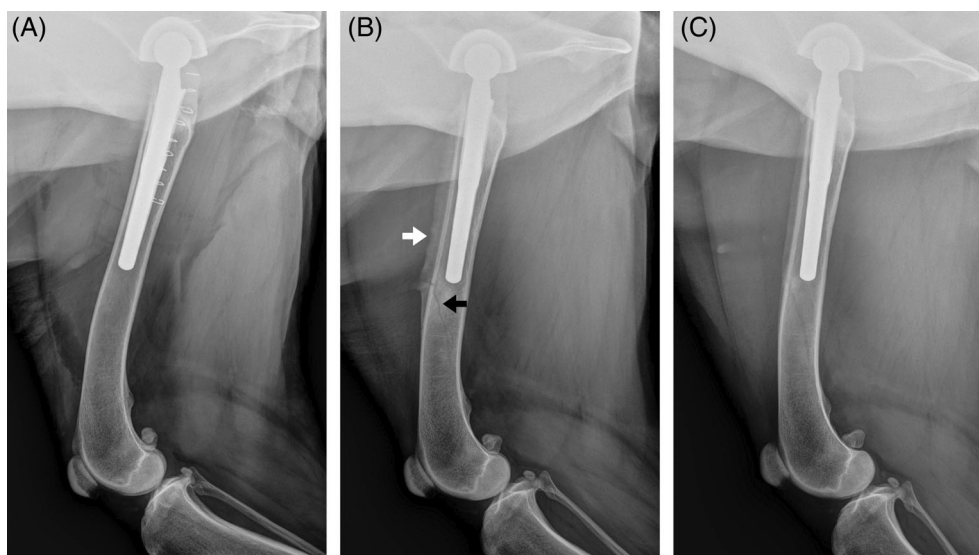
Radiographic projections of a postoperative nondisplaced femoral fissure. (A) Postoperative mediolateral projection showing appropriate implant placement with mild recurvatum tilt of the stem and no visible femoral fissure. (B) One month postoperatively with visible femoral fissure (black arrow) and minimal displacement just distal to the femoral stem. An exuberant periosteal reaction was observed (white arrow). Strict rest was recommended. (C) Three month postoperative radiographic projection showing remodeling of the periosteal reaction
